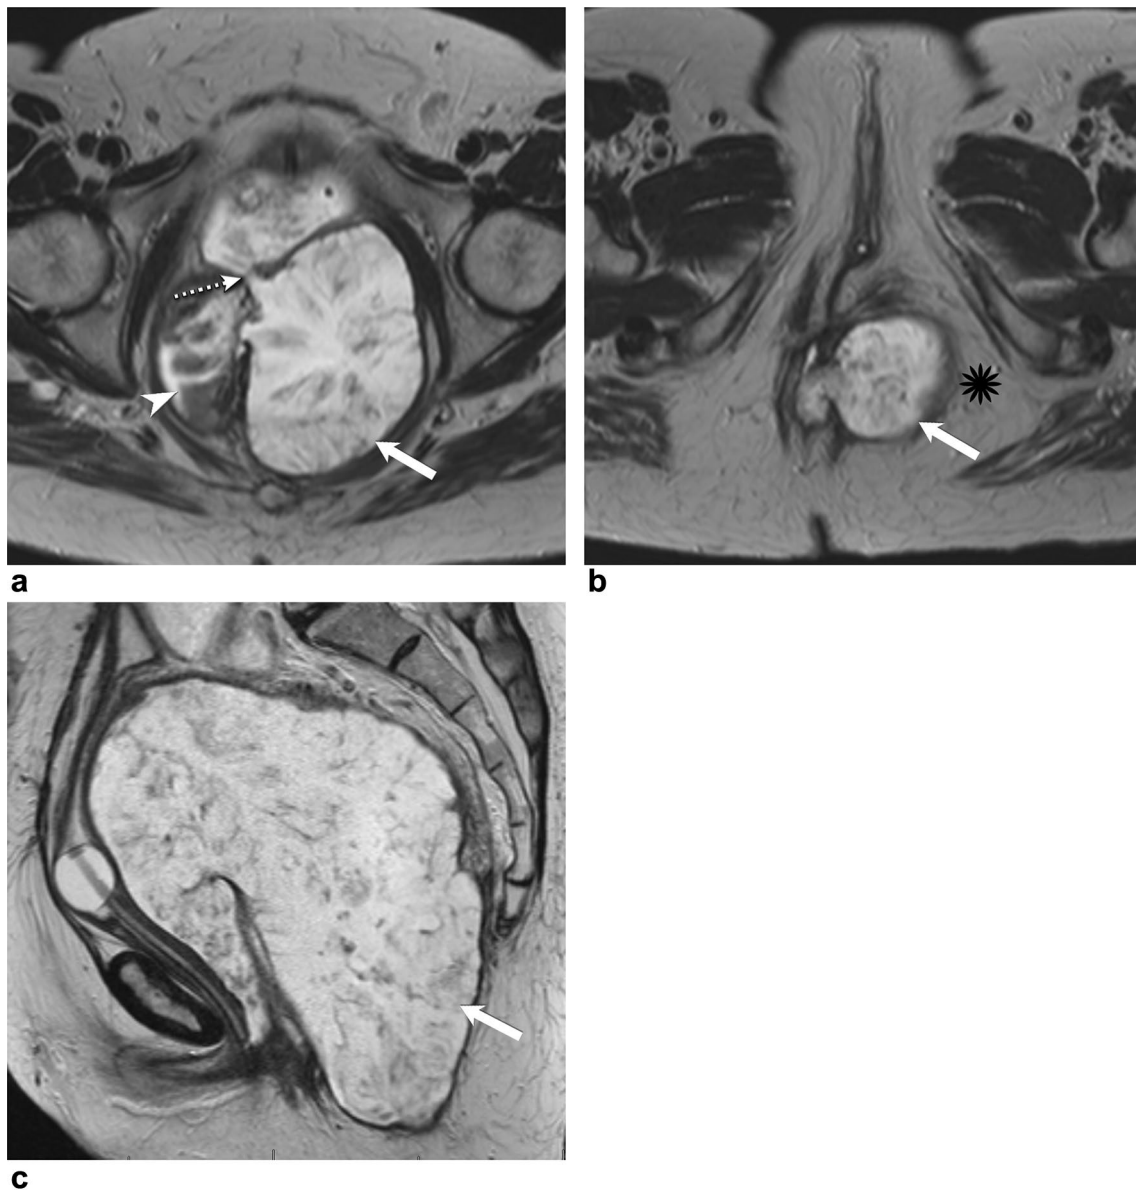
55-year-old female with locally advanced rectal adenocarcinoma on chemotherapy. She underwent pelvic MRI for assessment. Axial (a, b) and Sagittal (c) T2WI demonstrating a large polypoid rectal mass (white arrowhead) with a huge perirectal mucinous component (white arrow) that measures 15×7.5×3.8 cm. This tumor
